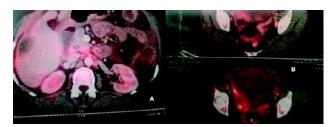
FDG avid peritoneal thickening (SUV max = 6; thickening = 9.5 mm) (A) and obdurator nodes (B) SUV max = 4.8.
